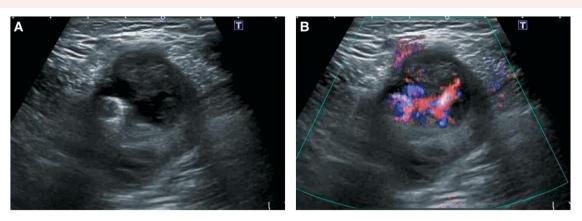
Duplex ultrasonography images of giant aneurysmal degeneration. Short-axis duplex images show a huge cavity outside the vessel (A) and a to-and-fro flow between the cavity and the SFA (B) at the location where two stents overlapped in the subintimal space. There was a continuous hypoechoic halo around the entire length of the Eluvia stents. See Supplementary material online, Video S1.
